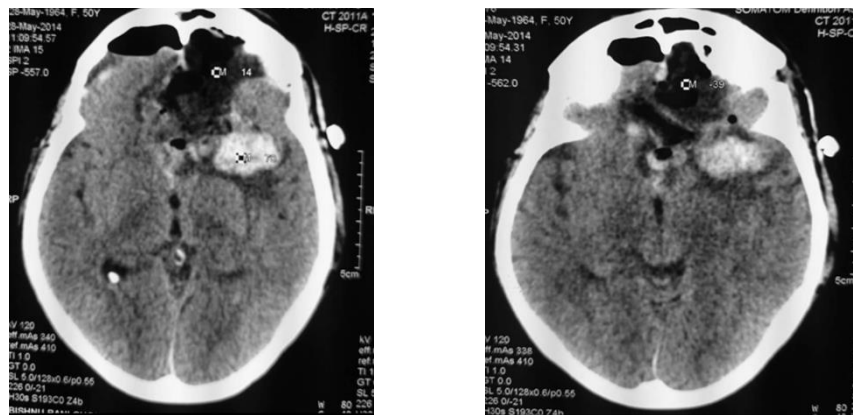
Postoperative CT showing olfactory groove meningioma after excision.
